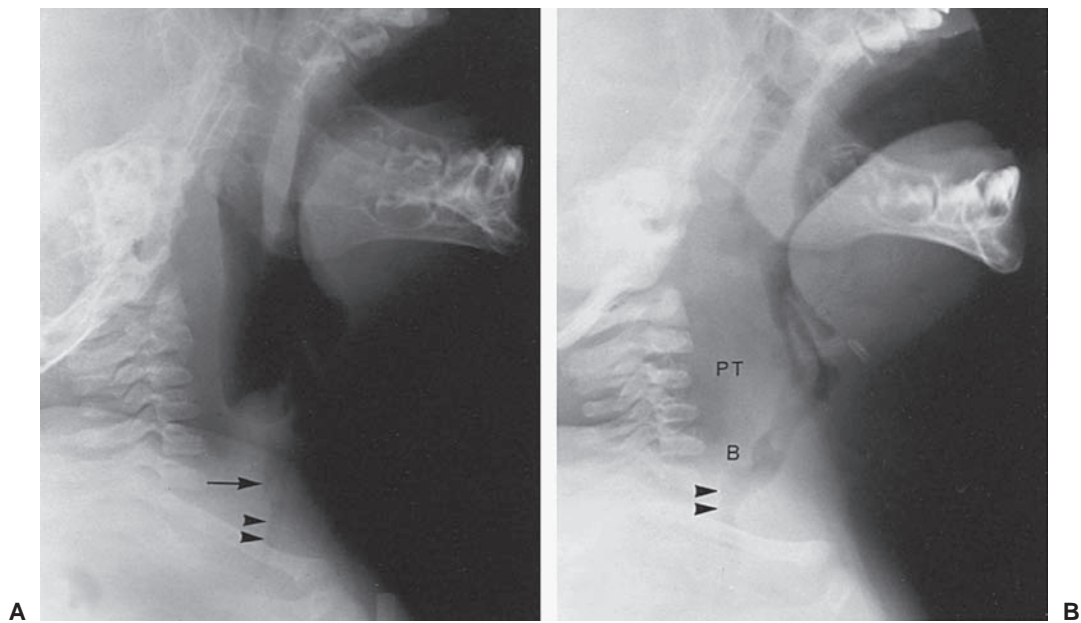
Inspiratory (A) and expiratory (B) lateral neck radiographs of a child with upper airway obstruction secondary to a granuloma (*arrow*) in the upper trachea. Note ballooning of the pharynx during inspiration (A) and narrowing of the trachea (*arrowheads*) below the level of obstruction. On expiration (B), note the normal pharyngeal lumen and dilation (*arrowheads*) of the trachea distal to the obstruction. The “bunching up” of the pharyngeal tissues (*PT*) and the buckling of the trachea (*B*) are normal findings on expiratory films.
